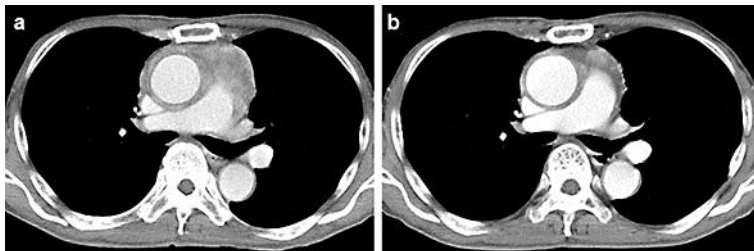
The findings of chest computed tomography scans after the administration of 2 and 4 cycles of carboplatin plus *nab*-paclitaxel therapy. a Chest computed tomography scan obtained after the administration of 2 cycles of the regimen. The tumor appears reduced in diameter. b Chest computed tomography scan taken after the administration of 4 cycles of the regimen. The tumor appears markedly reduced in diameter.
